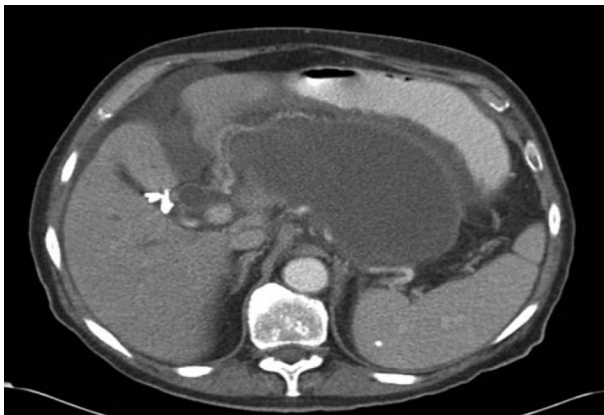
Abdominal computed tomography scan showing a pancreatic pseudocyst expanded anteriorly against the stomach
